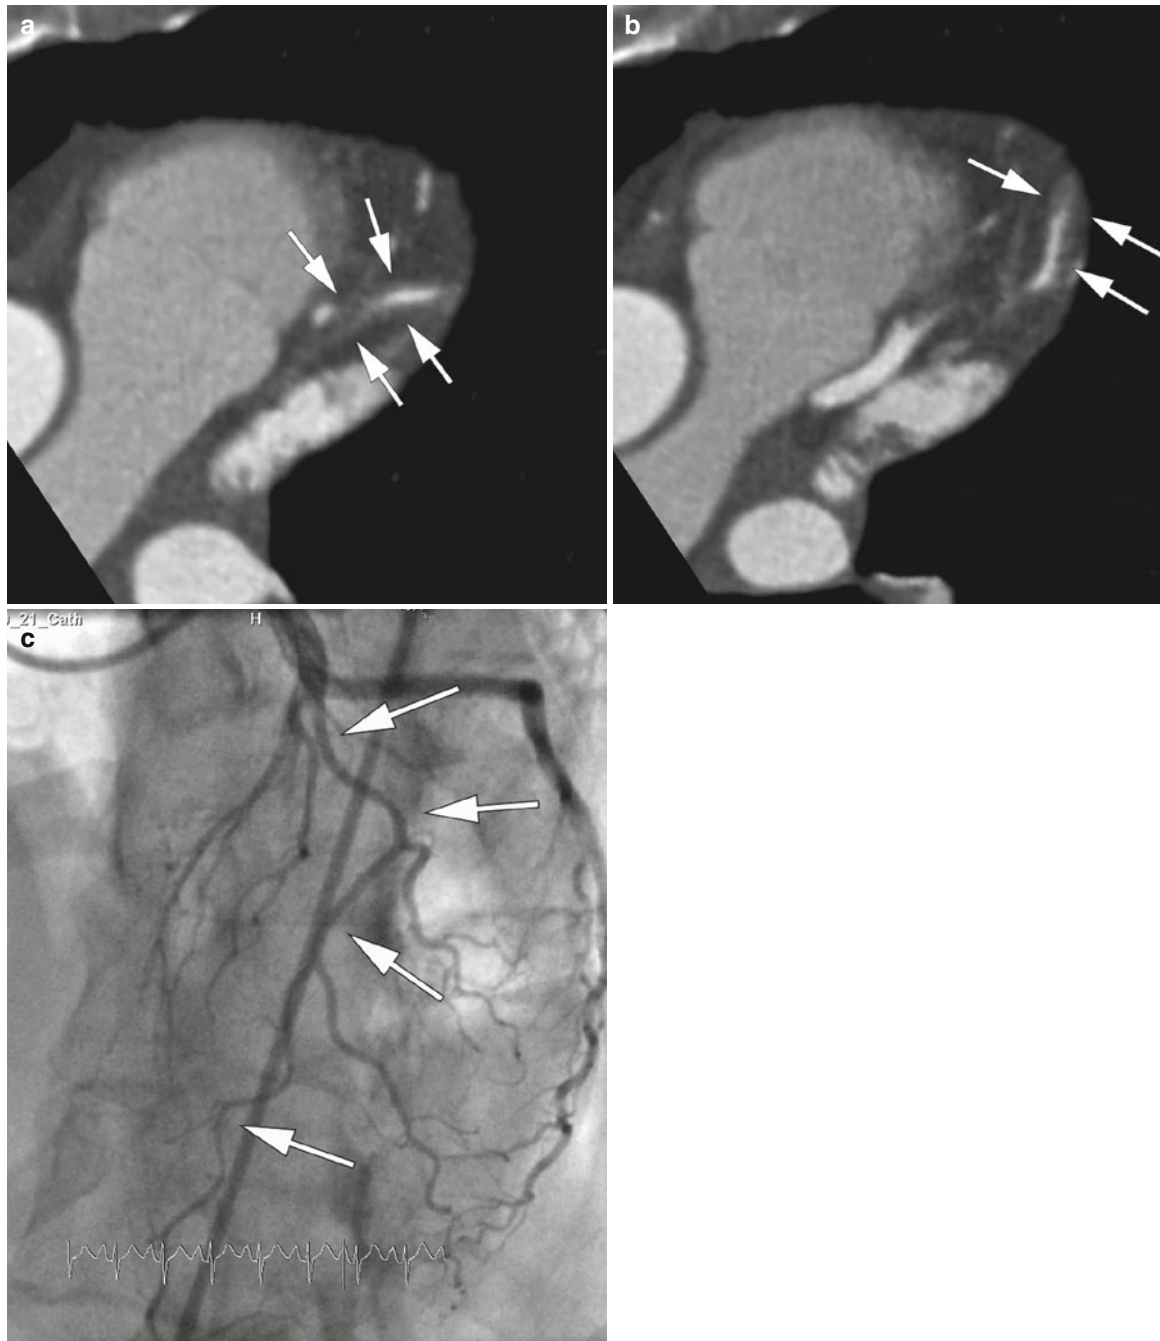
Chronic dissection of the proximal left anterior descending coronary artery. (a) and (b), Coronary CT angiography in transaxial orientation showing a longitudinal view of the left anterior descending coronary artery (a) and a cross-sectional view of the left anterior
